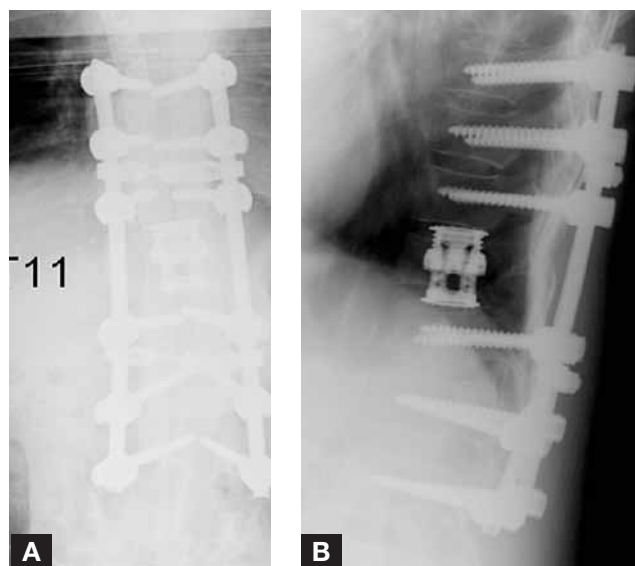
Postoperative lateral (A) and anteroposterior (B) plain radiographs obtained after posterior decompression, stabilization, and placement of cage through posterior lateral extra-cavitary approach. Patient regained ability to walk and was then treated with adjuvant spinal radiosurgery.
